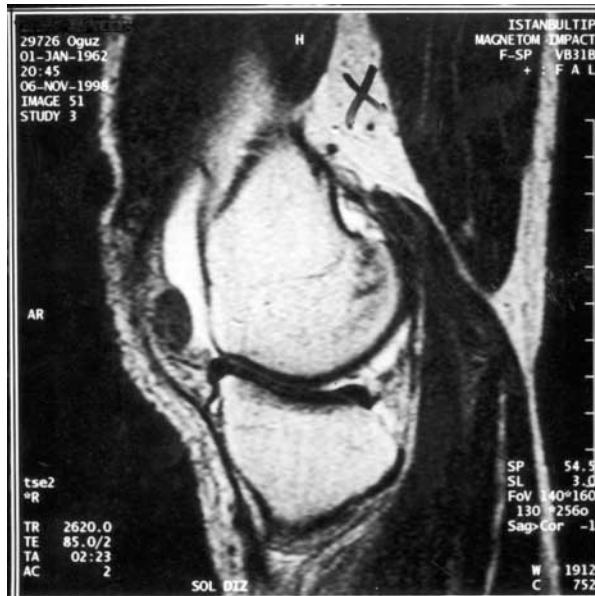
Case 1: MRI of the neoplasm (sagittal T1-weighted view).
